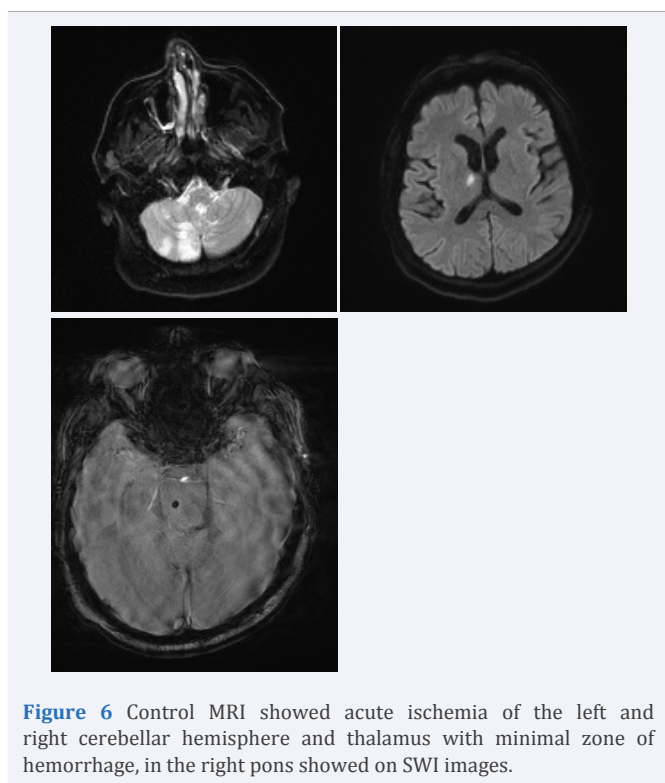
Control MRI showed acute ischemia of the left and right cerebellar hemisphere and thalamus with minimal zone of hemorrhage, in the right pons showed on SWI images.
